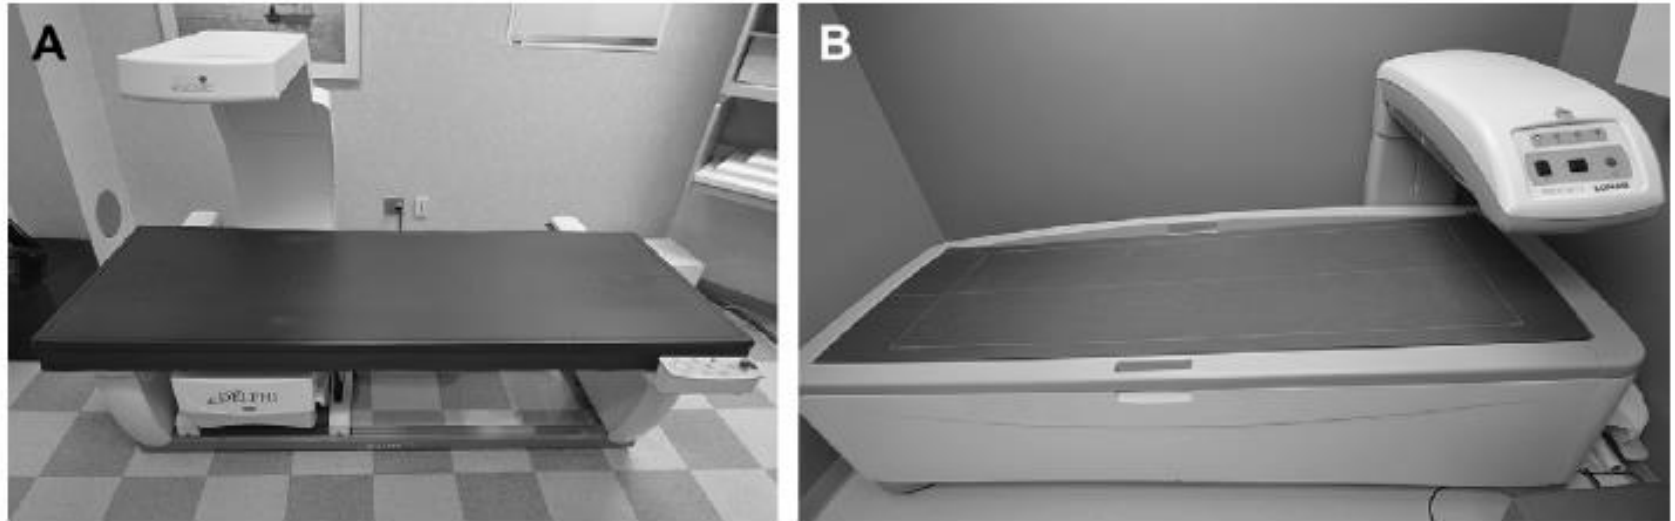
Central dual x-ray absorptiometry (DXA) scanners. (A) Hologic's Delphi fan-beam scanner. (B) General Electric's Prodigy fan-beam scanner.
